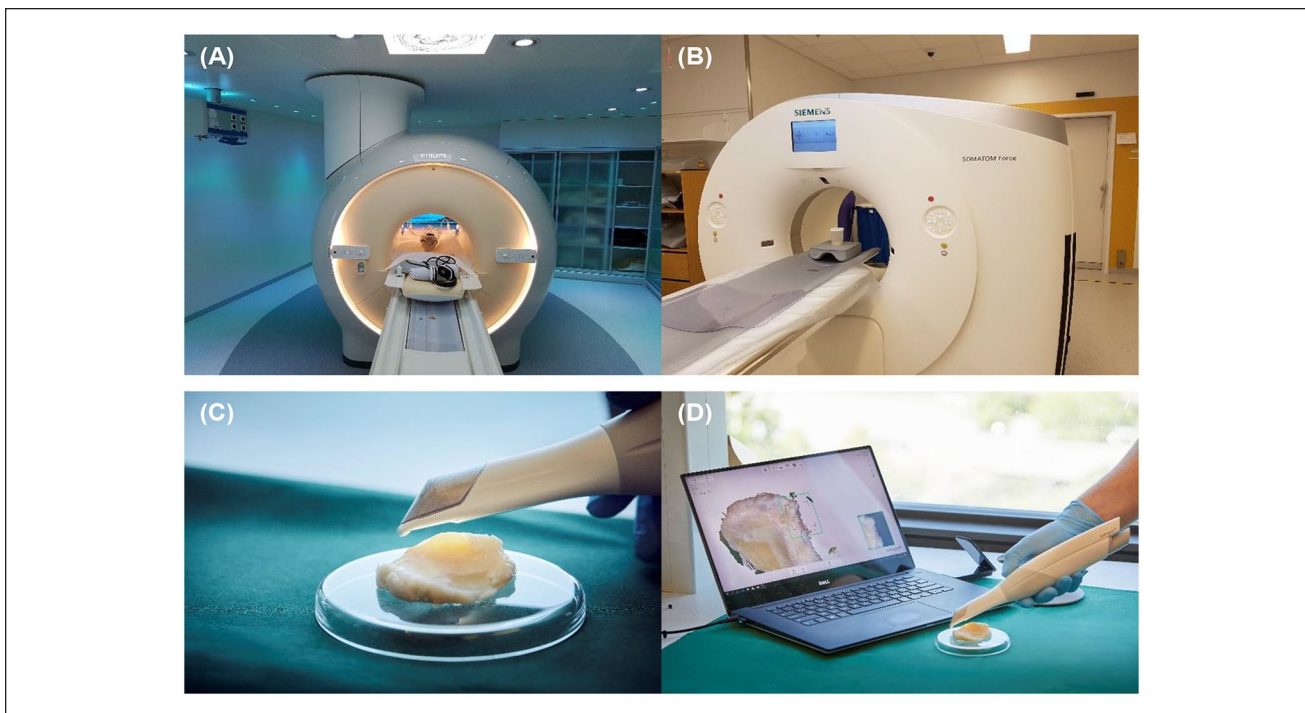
Instrument and experimental setup to generate data for analysis of the tibial plateau. (A) Magnetic resonance imaging (MRI) instrumentation setup. (B) Computed tomography (CT) instrumental setup. (C, D) Three-dimensional (3D) scanner experimental setup.
